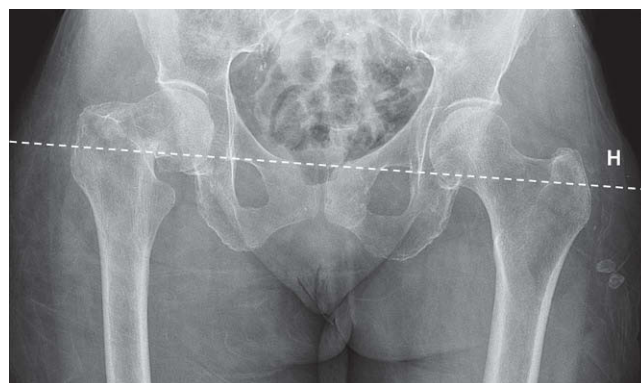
Anteroposterior pelvic radiograph of an 82-year-old patient with a subcapital fracture of the right femur. Planning started by tracing the horizontal (H) pelvic reference line drawn between the two teardrop images.
